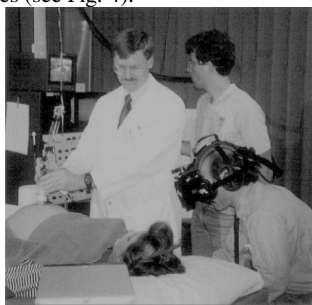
First video see-through HMD: Augmentation of ultrasound slices [12] 1992 ACM.
